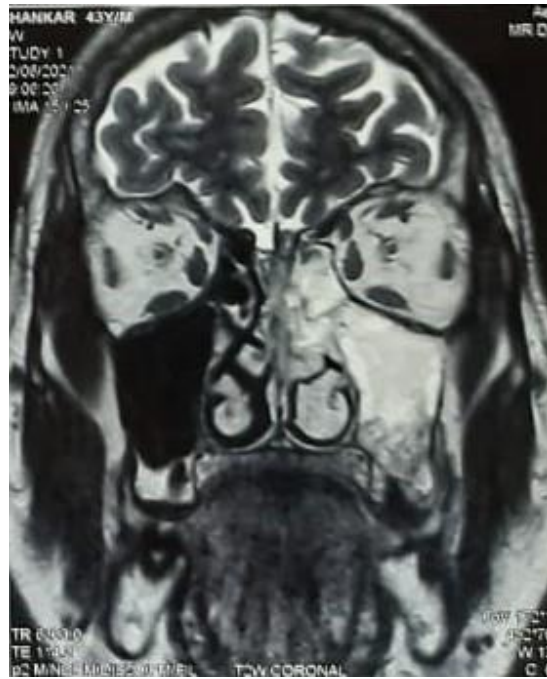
MRI PNS showing Dental abscess with secondary sinusitis
